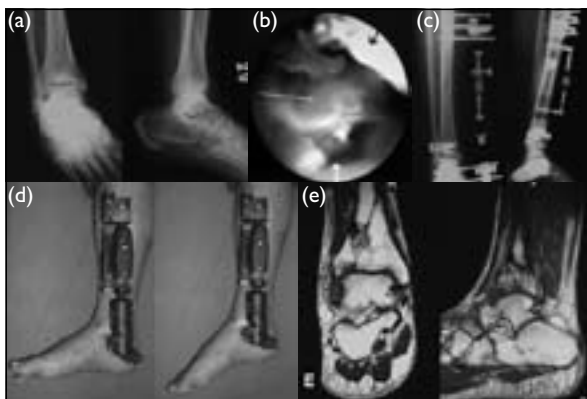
(a) Preoperative anteroposterior and lateral ankle direct radiography. (b) Articular surface reduction during arthroscopy; depressed articular surface (long white arrow), reduction probe (short white arrow), pilon of the tibia (short black arrow). (c) Postoperative early period, reduction achieved by unilateral external fixator and minimally invasive screw osteosynthesis. (d) Four weeks postoperative, external fixator hinge opened and ankle motion started. (e) T1-weighted magnetic resonance imaging done 2 years after the operation show at step-off of less than 1 mm
